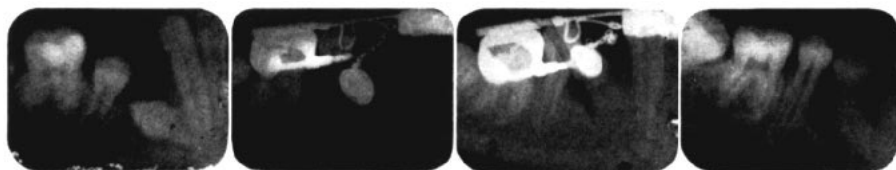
Four X-rays showing the progress in the eruption of the lower right first bicuspid.
